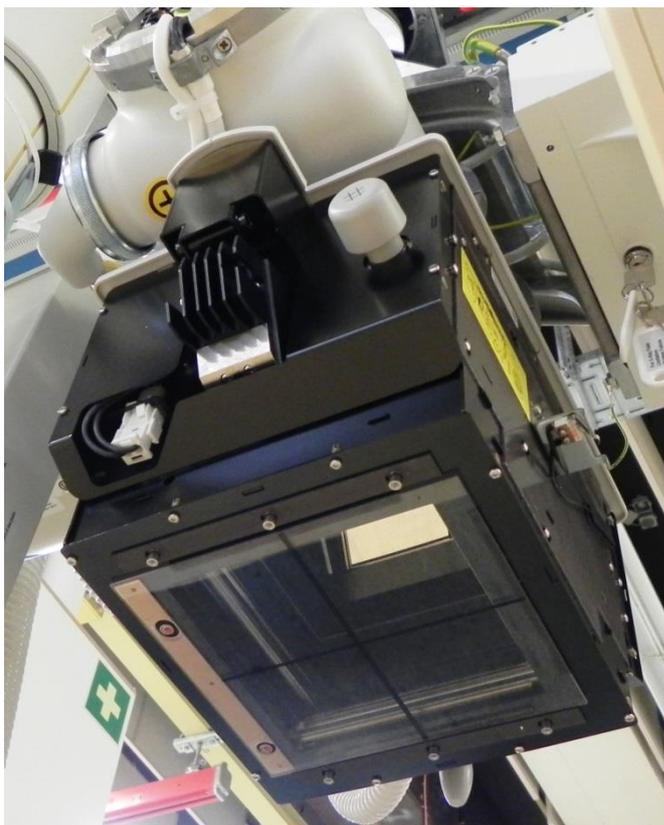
Current beam limiting device from Philips, with beam limiting apertures which allows adding of additional X-ray filtration. The cover was removed.
